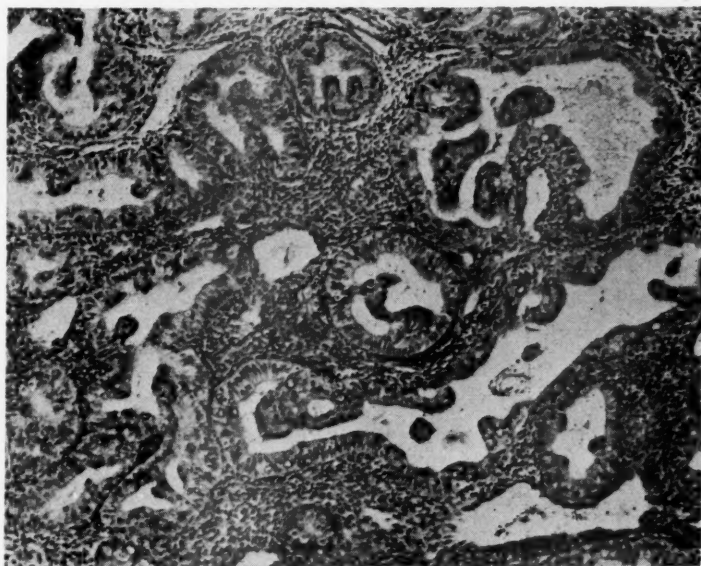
Patient, aged 49 years, had had x-ray induction of menopause four years previously. For some months before curettage the patient had taken 1 mg. stilbestrol daily for menopausal symptoms, followed by bleeding five days after withdrawal of drug. Picture shown above had been diagnosed adenocarcinoma, but was considered by us to be benign. Repetition of curettage four or five weeks later showed regression of endometrium to extreme senile atrophy (see Fig. 2).
